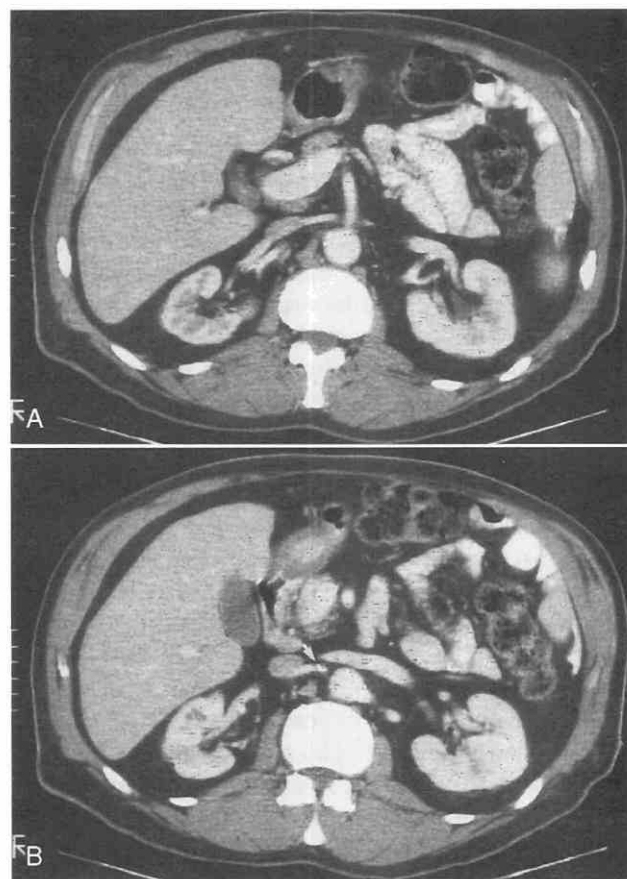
Right renal artery stenosis. A, Dynamic CT scan after a rapid intravenous injection of contrast agent shows prolonged corticomedullary differentiation in the right kidney as compared with the left kidney, for which the nephrogram is almost homogeneously dense. The right kidney also shows global atrophy. B, A contiguous caudal image reveals a calcified atherosclerotic plaque (arrow) at the origin of the right renal artery. (From Birnbaum BA, Bosniak MA, Megibow AJ: Asymmetry of the renal nephrogram on CT: Significance of the unilateral prolonged cortical nephrogram. *Urol Radiol* 12:173-177, 1991.)
